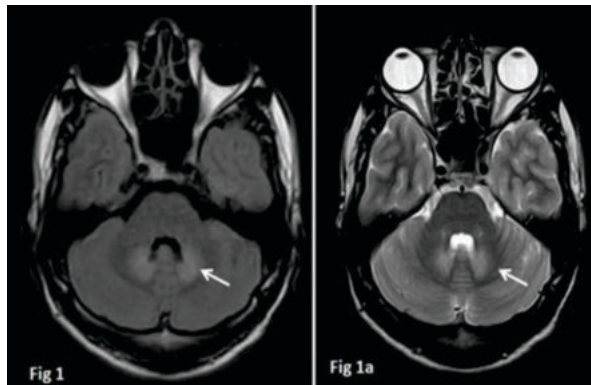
MRI axial T2 FLAIR and T2 (1a) weighted images show symmetric hyperintense signal intensity in the dentate nuclei (arrows)
